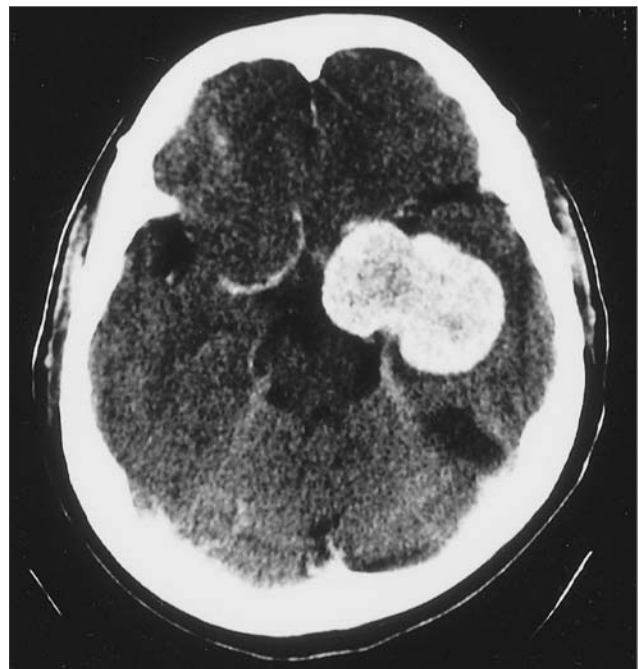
Case 1: Preoperative contrast axial CT scan shows enhancing of tumoral mass on the left temporal lobe.
